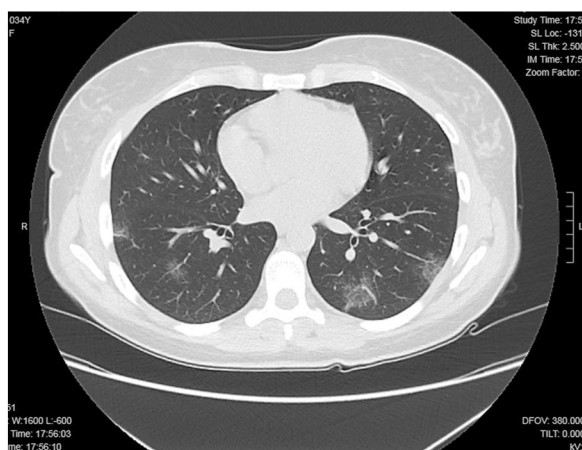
High-resolution computed tomography scan of the chest reveals marked improvement, with only minimal residual subpleural infiltrates.
